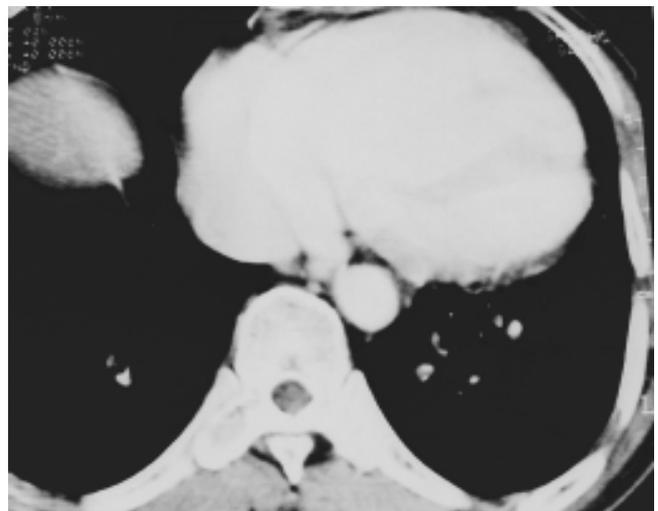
"CTA showing filling defect in bilateral lower lobe segmental arteries.
